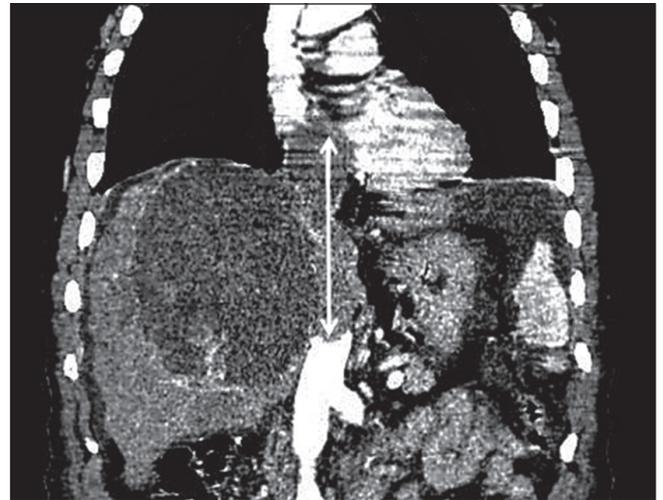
Abdominal CT reconstruction showing the presence of a large hepatic mass (13 cm in diameter) invading the inferior vena cava and extending all the way to the right atrium (double-arrow).
